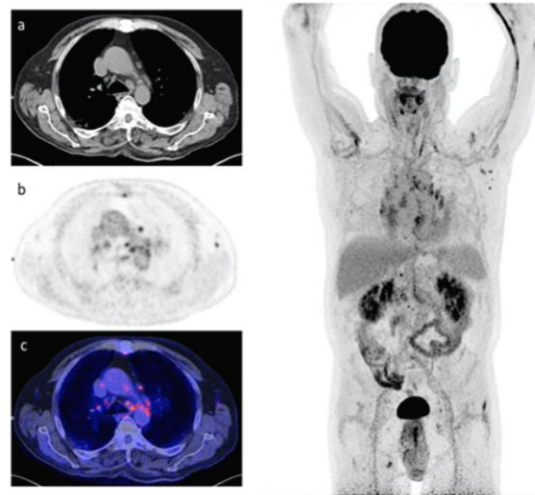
A 64-year man admitted for multilobar pneumonia caused by SARS-CoV-2. The [¹⁸F]FDG-PET/CT at 3 months after symptom onset shows increased [¹⁸F]FDG uptake in residual pulmonary lesions (TLG 124,11) and mediastinum lymph node (SUV_{peak} 1,73). Pulmonary function tests evidenced severe pulmonary diffusion impairment, with a diffusing capacity of the lungs for carbon monoxide 41% of the predicted value. Left: (a) CT transverse slice, (b) [¹⁸F]FDG-PET slice, and (c) fused [¹⁸F]FDG-PET and CT images. Right: whole-body, maximal intensity projection image, displaying mediastinal lymph nodes with [¹⁸F]FDG uptake.
